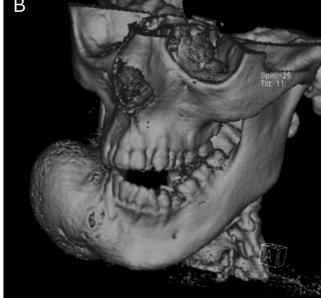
A and B 3D CT reconstruction 35 months later showing extension of the lesion across the midline with marked bony expansion.
